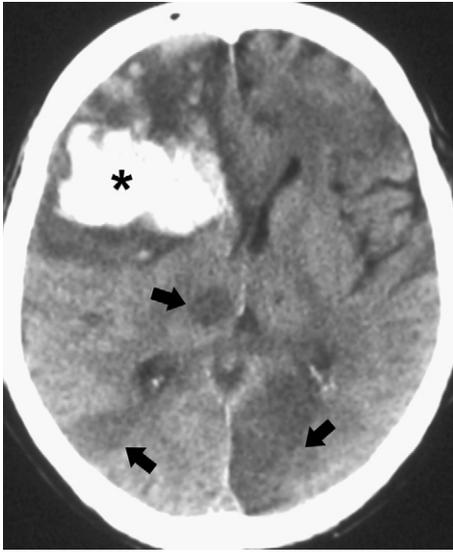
Phaeohyphomycosis: brain infarcts caused by *Bipolaris*. Non-enhanced axial CT scan at the level of the frontal horns shows a large hemorrhagic infarct (asterisk) in the right frontal lobe and multiple bland infarcts involving both cerebral hemispheres (arrows).
